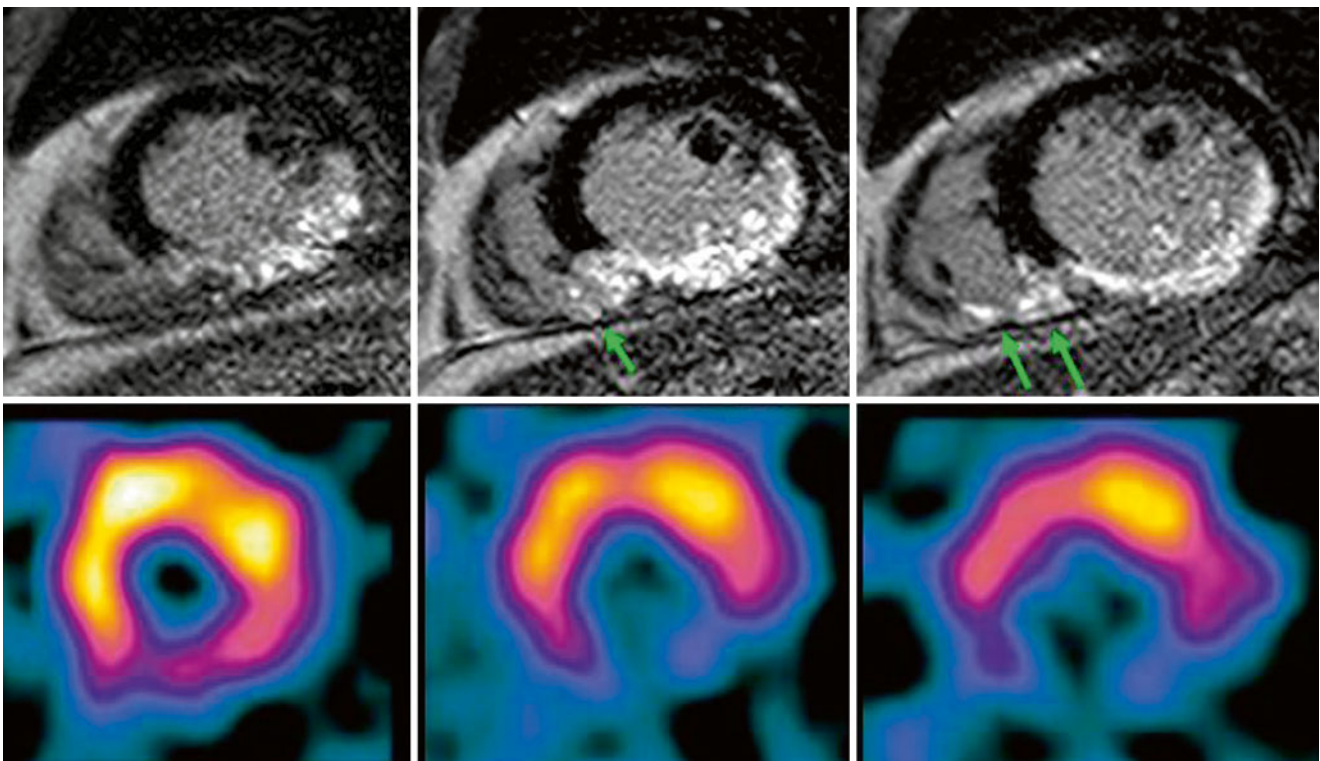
LGE comparison with SPECT for RV infarction. LGE (top image) clearly shows RV infarction. (arrows) as well as inferior LV myocardial infarction. However, SPECT shows only perfusion defect at inferior wall of LV myocardium
